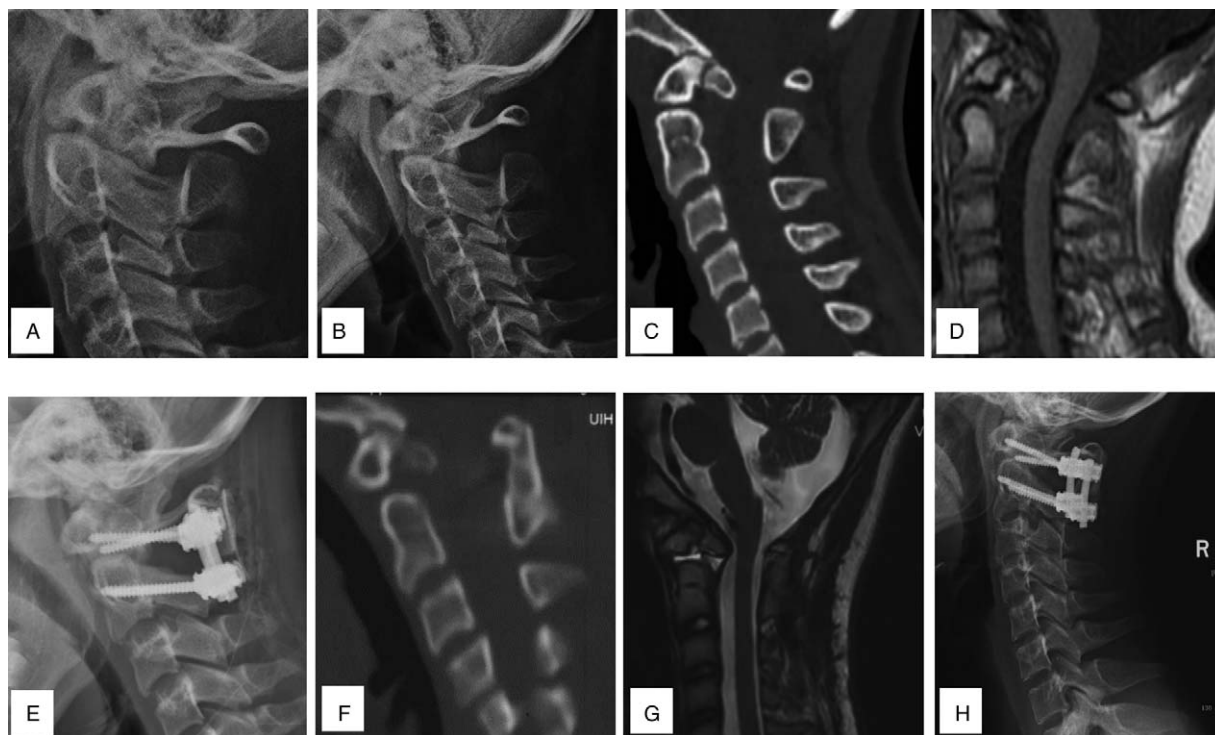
A case of os odontoideum-associated atlantoaxial dislocation. A 13-year-old female presented with obstructed neck movement for 1 year. (A) and (B) Lateral cervical X-ray and in a neutral position and flexion position showed OO-associated AAD. (C) The preoperative CT showed the backward atlantoaxial dislocation with OO (the instability index was 50%). (D) Pre-operative MRI showed ventral compression of the cervical spinal cord (CMA = 130°). (E) Postoperative X-ray showed the realignment of the C1 and C2 vertebrae. (F) Postoperative sagittal CT showed good and realignment of C1 and C2 joints and the longer trajectory of C2 pedicle screw. (G) Posterior MRI showed complete decompression of spinal cord (CMA = 144°). (H) At the 2-year follow-up, there no kyphosis or crankshaft phenomenon were identified in this patient. CMA: Cervicomedullary angle; CT: Computerized tomography; MRI: Magnetic resonance imaging; OO: Os odontoideum.
